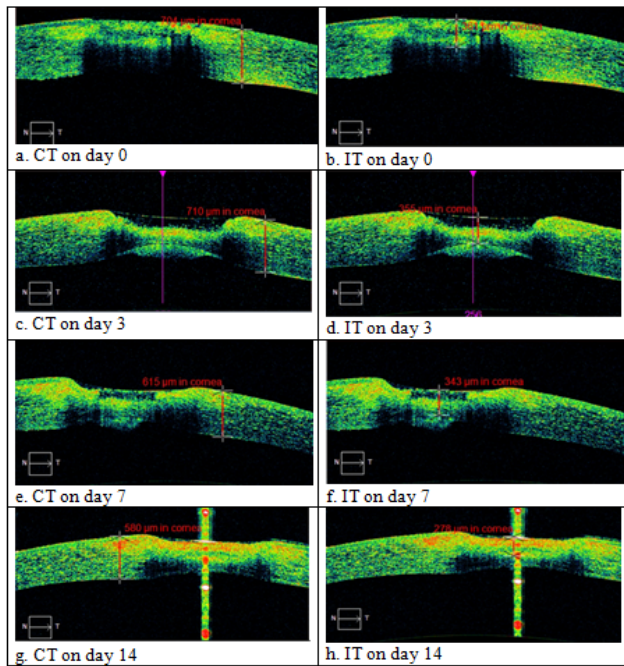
A representative case showing progressive decrease in CT and IT in resolving microbial keratitis
